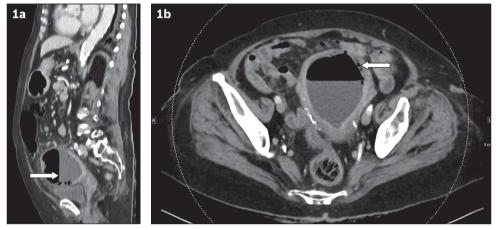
(a) Sagittal and (b) axial contrast-enhanced CT images of the abdomen and pelvis.
